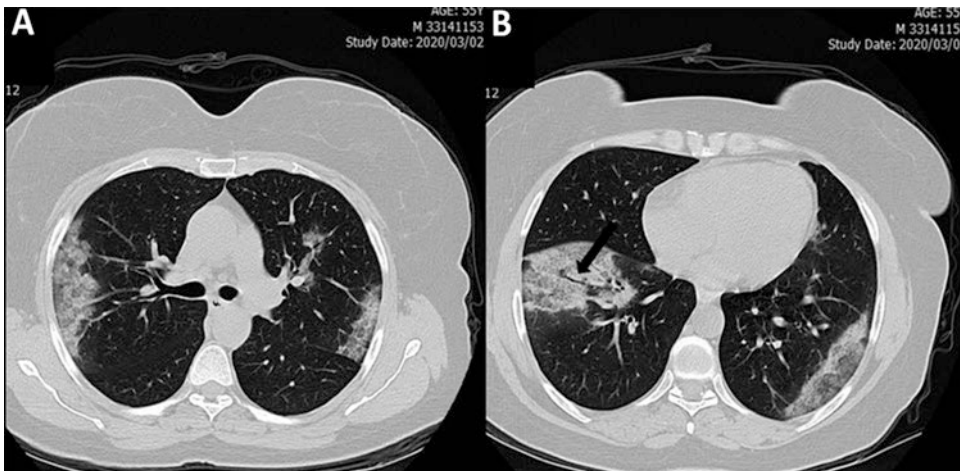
Two axial chest CT scans without contrast in a 55-year-old female with COVID-19 pneumonia show (a) a bilateral multifocal and subpleural patchy crazy-paving
